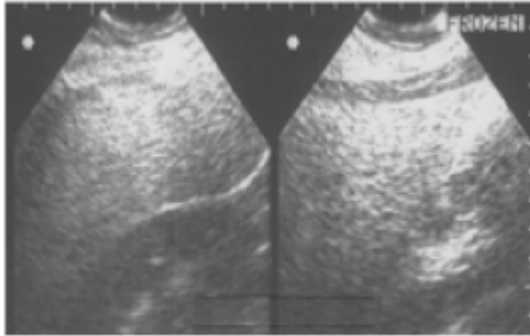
Ultrasound image for bright liver.
